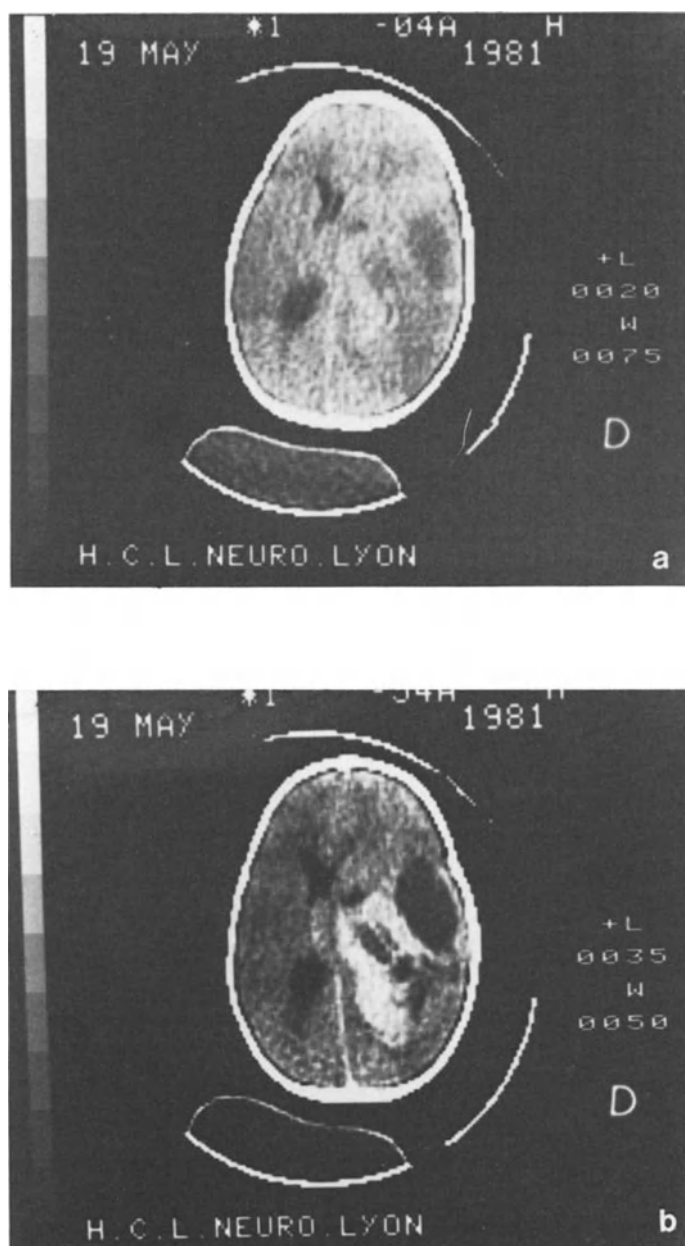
Grade II infantile ependymoma. a) Pre-contrast CT. b) Post-contrast CT exhibits associated areas of enhancement and of necrosis
